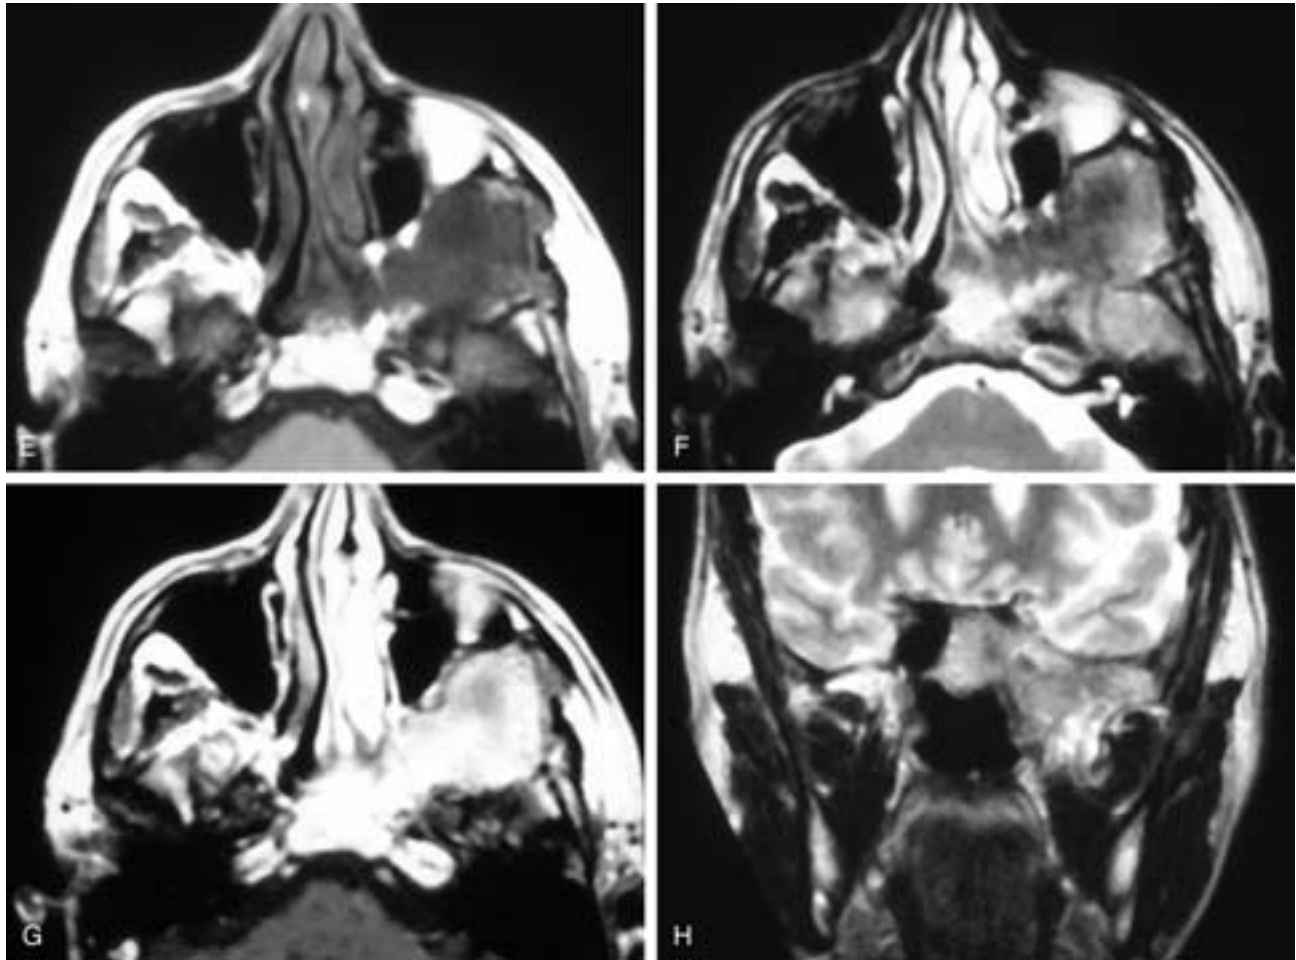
Continued.* Axial T1-weighted (E), T2-weighted (F), and T1-weighted, contrast-enhanced (G) MR images and a coronal T2-weighted (H) MR image show the low to intermediate T1-weighted and T2-weighted signal intensity and the marked enhancement of the process. This patient had fibrous dysplasia.
